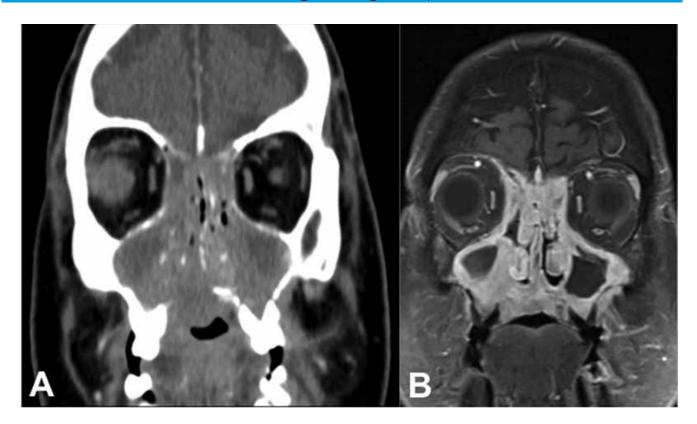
A) CT shows a bilateral ethmoid and maxillary opacity, with signs of bone erosion of the maxillary sinus walls and hard palate; B) MRI reveals an almost total opacity of the paranasal sinuses with erosion of the maxillary sinus, lamina papyracea and cribriform plate and bilateral extension to the malar fat
